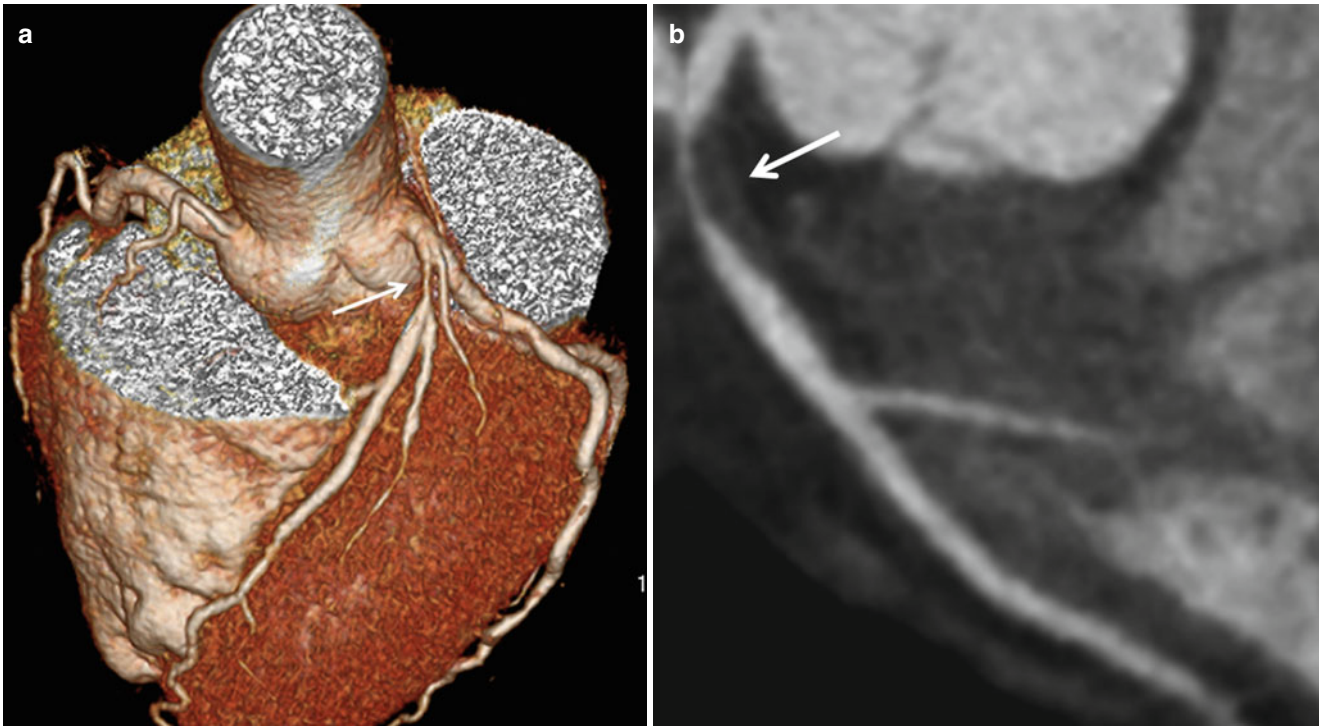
Coronary computed tomographic angiography (CCTA) with significant coronary artery stenosis of the left anterior descending artery (LAD). (a) Volume rendering (VR) image demonstrates significant coronary artery stenosis in the proximal segment of LAD
